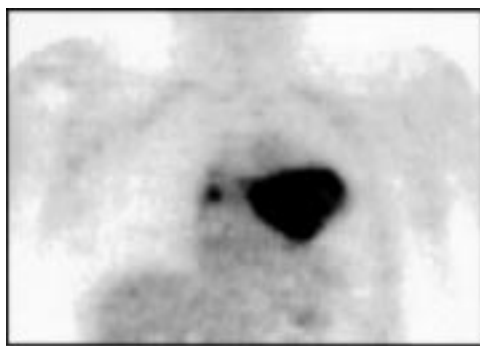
Coronal FDG-PET image of a patient with squamous cell carcinoma stage IIIb. The primary tumour, as well as the pathologically proved contralateral mediastinal lymph node metastasis, shows intense uptake of FDG corresponding to N3 disease.
